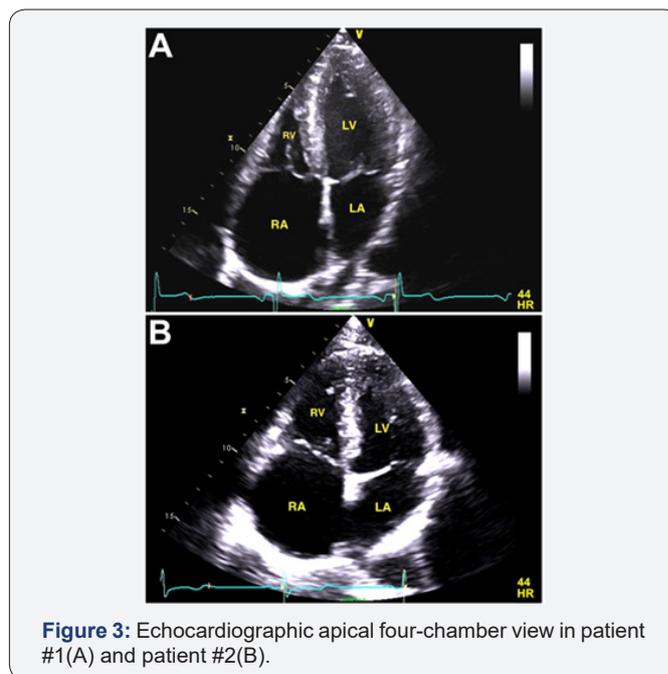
Echocardiographic apical four-chamber view in patient #1(A) and patient #2(B).
